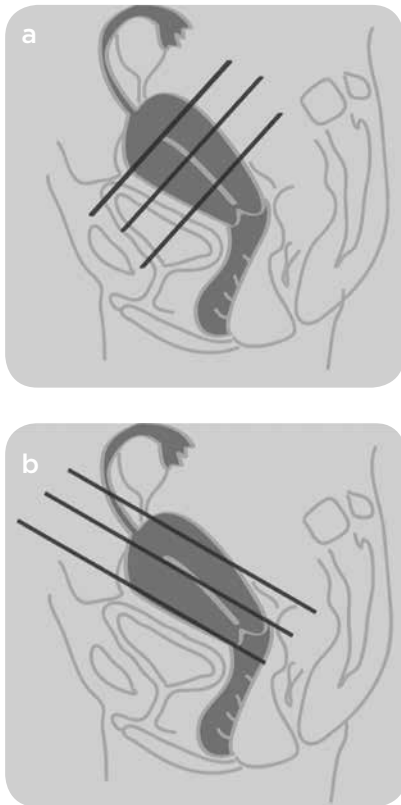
Acquisition of MR images. a) Oblique coronal plane to the major axis of the uterus and b) axial or perpendicular to the long uterine axis.
